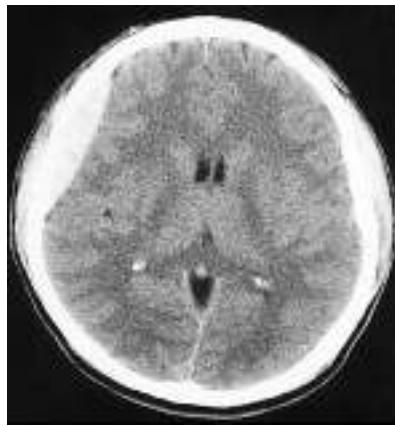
Acute epidural hematoma. The tightly attached dura is stripped from the inner table of the skull, producing a characteristic lenticular-shaped hemorrhage on noncontrast CT scan. Epidural hematomas are usually caused by tearing of the middle meningeal artery following fracture of the temporal bone.
